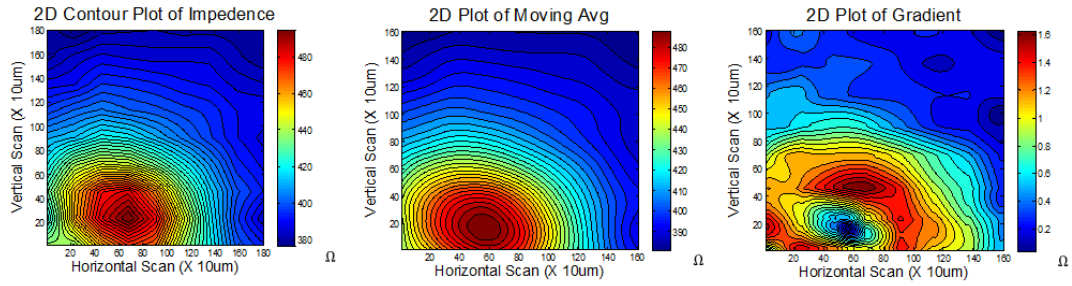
Figure a. Image of scanned impedance change for MRI derived brain model
